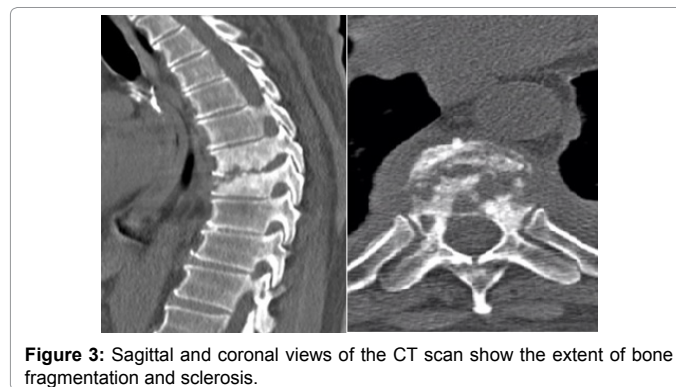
Sagittal and coronal views of the CT scan show the extent of bone fragmentation and sclerosis.
